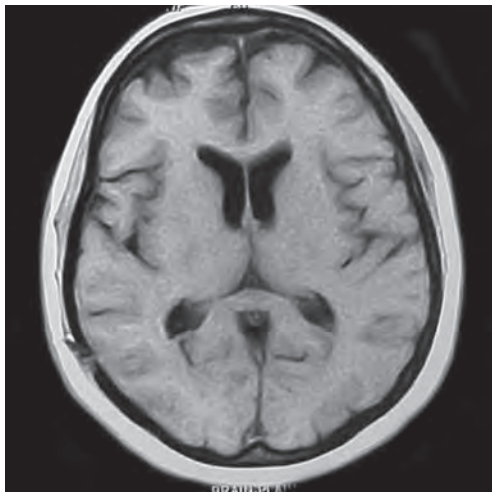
Post-operative MRI of the same patient as in Figure 3A showing total removal
